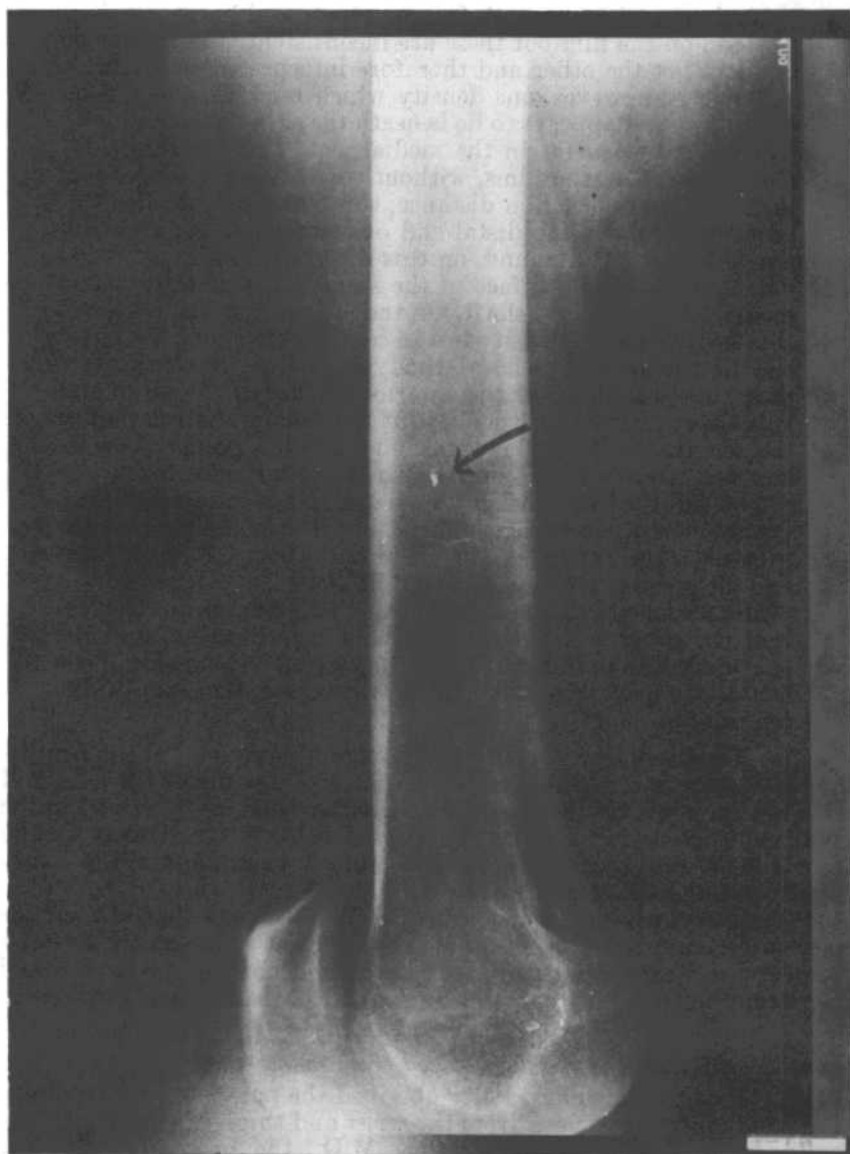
Photograph of a LogEtronic enhancement of a thigh X-ray, showing the location of the missile fragment in the subcutaneous fat.
